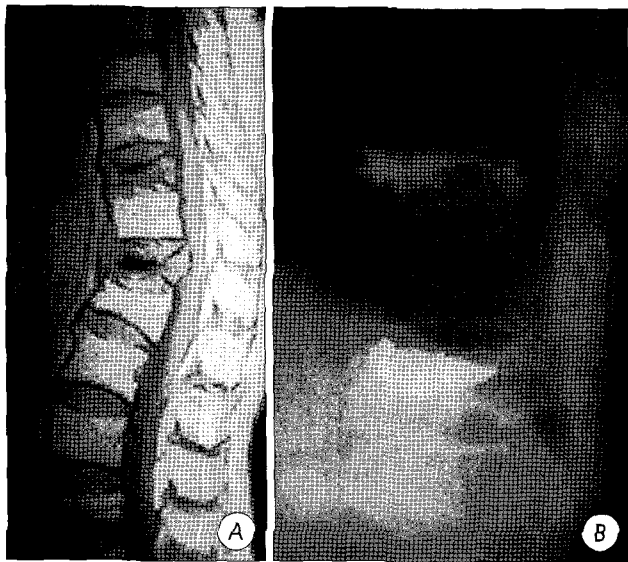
Images in a 80-year-old woman with T10 and T12 compression fracture. A : Sagittal magnetic resonance image shows T10 compression fracture and T12 vertebra plana (about 85% vertebral body collapse). B : Lateral x-ray obtained after injection of methylmethacrylate. There is a good anterior filling of the vertebral body without any evidence of leakage into the epidural space.
